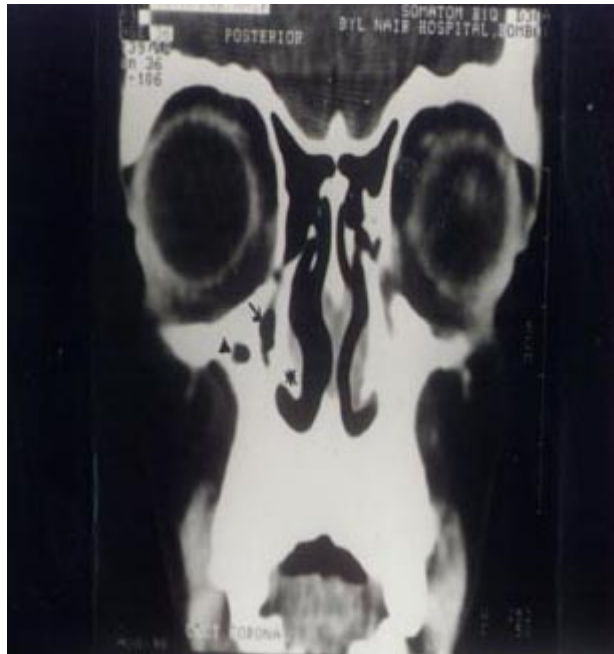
Coronal cut of CT scan of paranasal sinuses showing,* the inferior turbinate, partially blocked nasolacrimal duct, Z anteriormost limit of the maxillary sinus.
